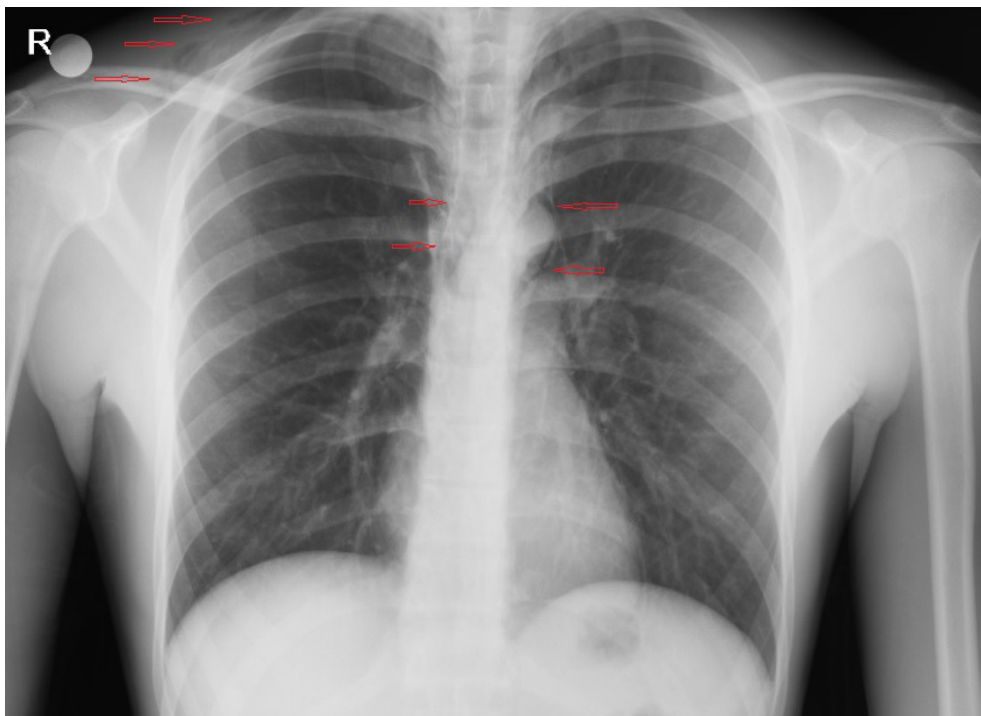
Posterior-anterior (PA) chest X-RAY showed diffuse subcutaneous emphysema in neck and chest wall along with pneumomediastinum.
